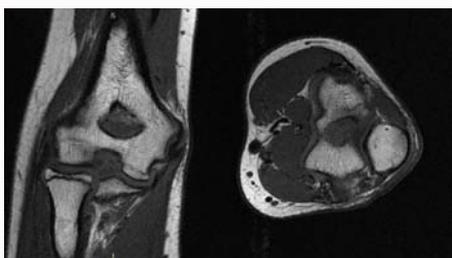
MRI of the left elbow.
